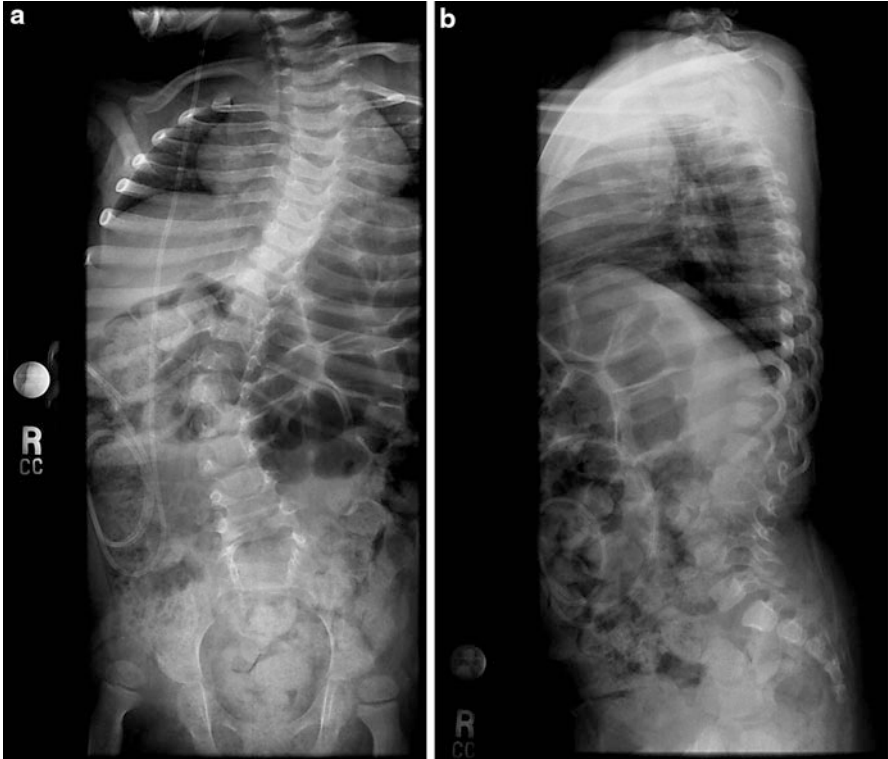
Frontal radiograph of a 5-year-old boy with Chiari II malformation shows the absence of spinous processes in the lower lumbosacral region with widened pedicles due to the meningocele (a). Lateral radiograph (b)
